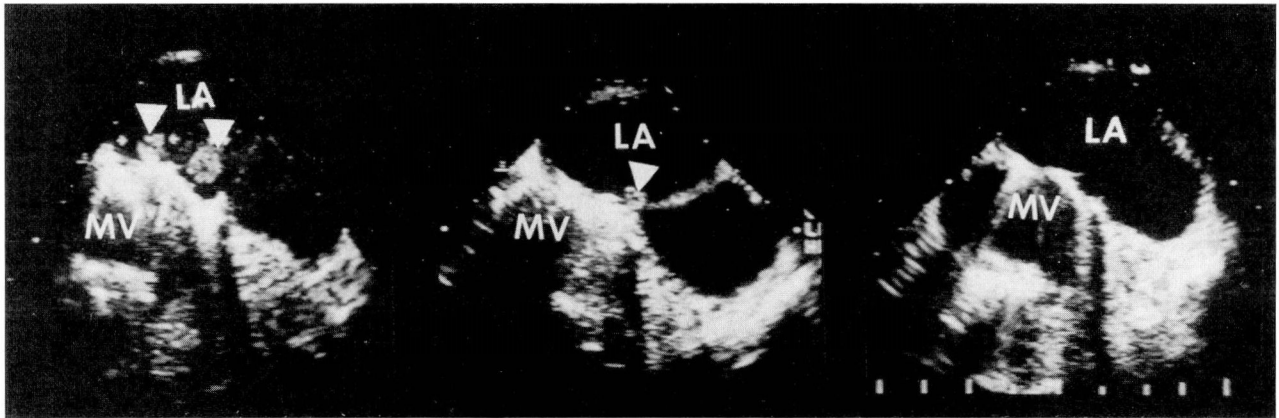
Transesophageal echocardiogram showing two mobile masses (arrow heads) attached to the left atrial side of the mitral valve prosthesis (left), partial resolution after urokinase treatment at 24 hours (middle), and complete resolution of the masses 9 days later (right). (LA, left atrium; MV, mitral valve)
